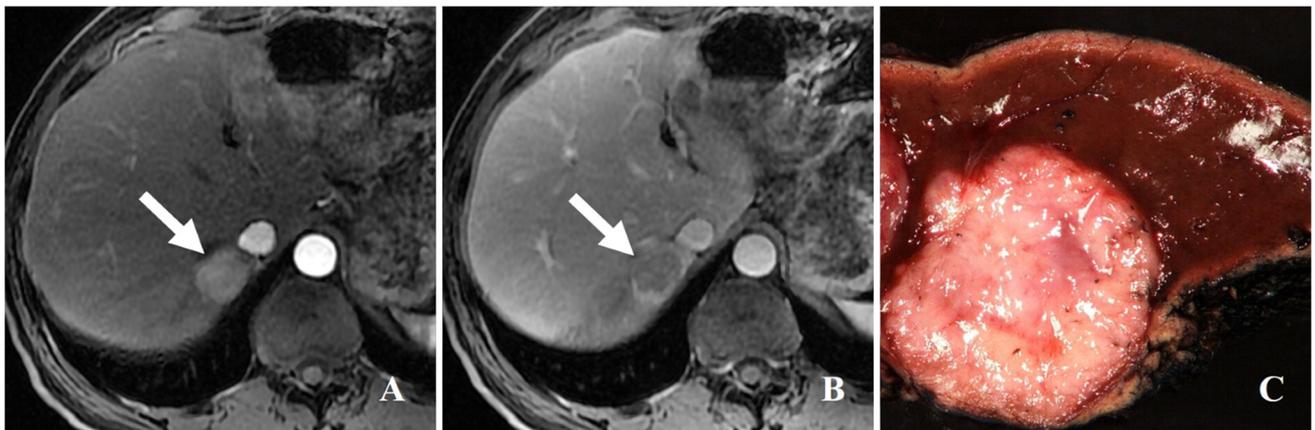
66-year-old man with HBV-related cirrhosis. Axial 3D-GRE gadobenate-MRI images obtained during the hepatic arterial phase (HAP) (a) and portal venous phase (PVP) (b) show a 4.0 cm LR-5 observation showing non-rim arterial
